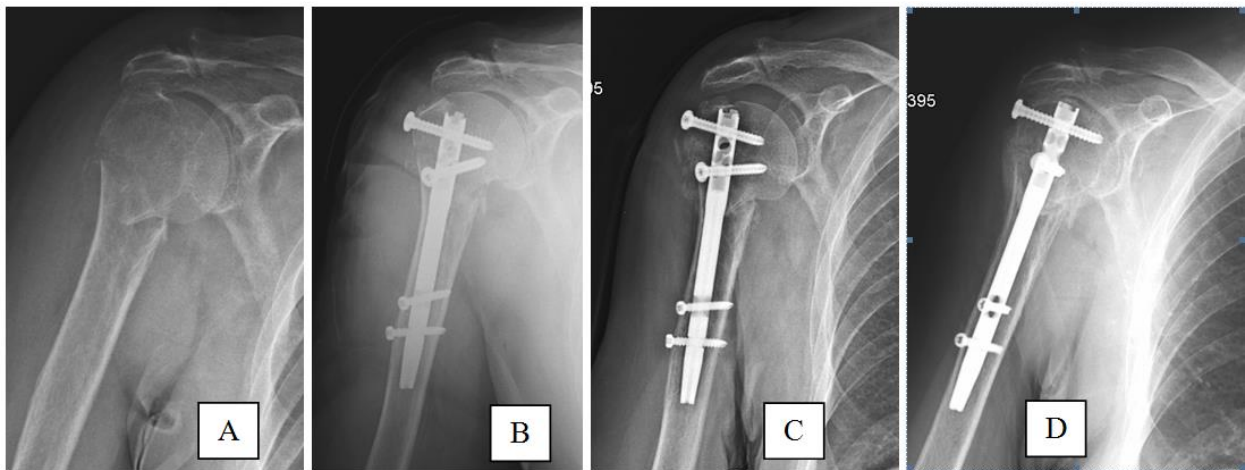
Preoperative X-Ray image (A), After surgery X-Ray image (B), One month after surgery X-Ray image (C), Follow up 3 months after surgery X-Ray image (D).
